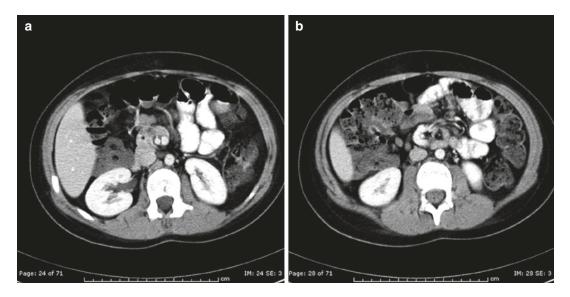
CT study of an eight year child undergoing staging of a lymphoma, led to an incidental finding of malrotation. The axial images of the upper abdomen
